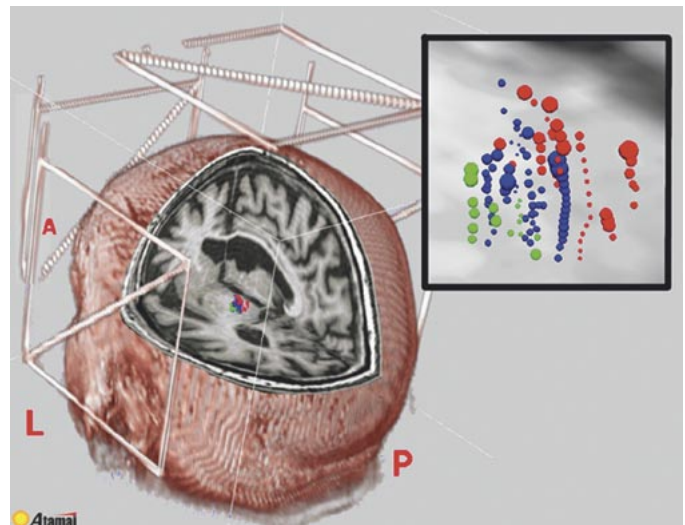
Posterior view of a volume rendered patient preoperative MRI scan. Cutaway reveals cluster of data extracted from the database following nonlinear registration to this imaging volume. The fiducial bars are visible surrounding the patient's head. (inset) Magnification of data extracted from the database encoding for paresthetic responses characteristic of the Vc sensory nucleus. All responses were evoked using microstimulation with less than $100\text{-}\mu\text{A}$ current at 300 Hz. Note the medial to lateral somatotopic organization of these population data (face medial to foot lateral): Red—Paresthesias of the mouth and tongue. Blue—Paresthesias of the contralateral fingers. Green—Paresthesias of the contralateral foot. Data were procured from 15 patients. *P*: posterior, *L*: left, *A*: anterior.
